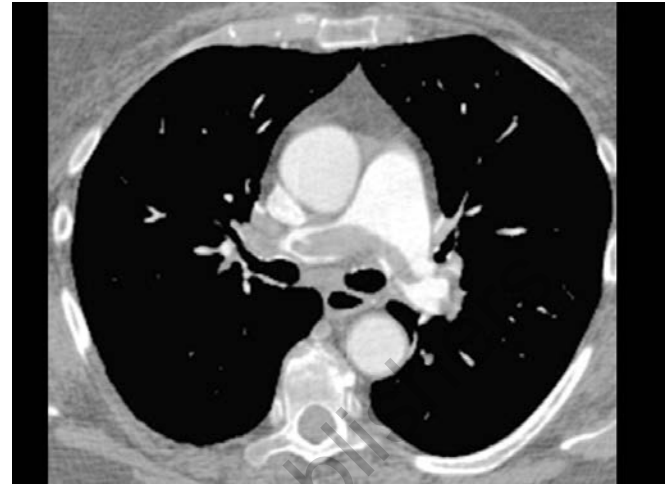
CT angiogram showing a large filling defect at the division of the right and left main pulmonary arteries. This is also known as a saddle embolism. Note the acute angle formed by the embolus and the contrast-filled lumen
